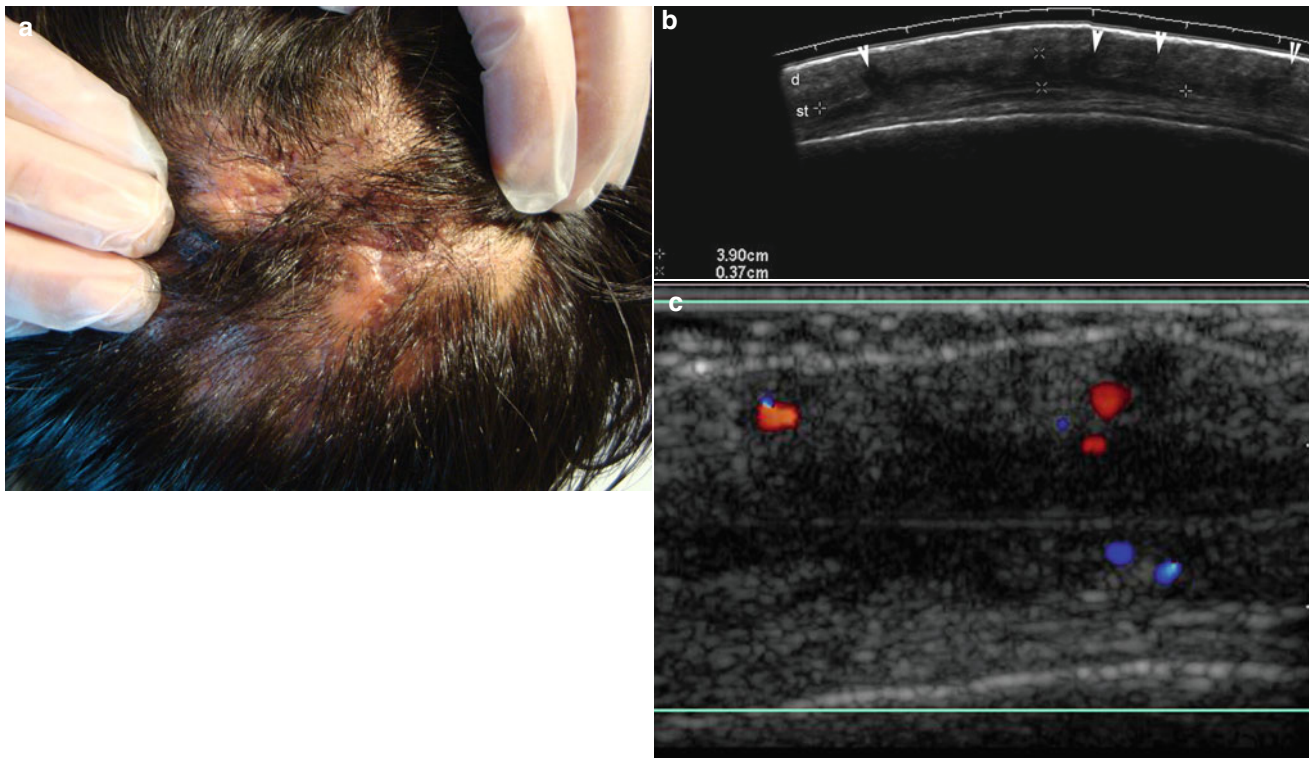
(a, b) Acne keloidalis nuchae. (a, b) Grey scale ultrasound images (transverse view; c outlined) demonstrate multiple and connecting fistulous tracts (o) in the occipital region of the scalp
